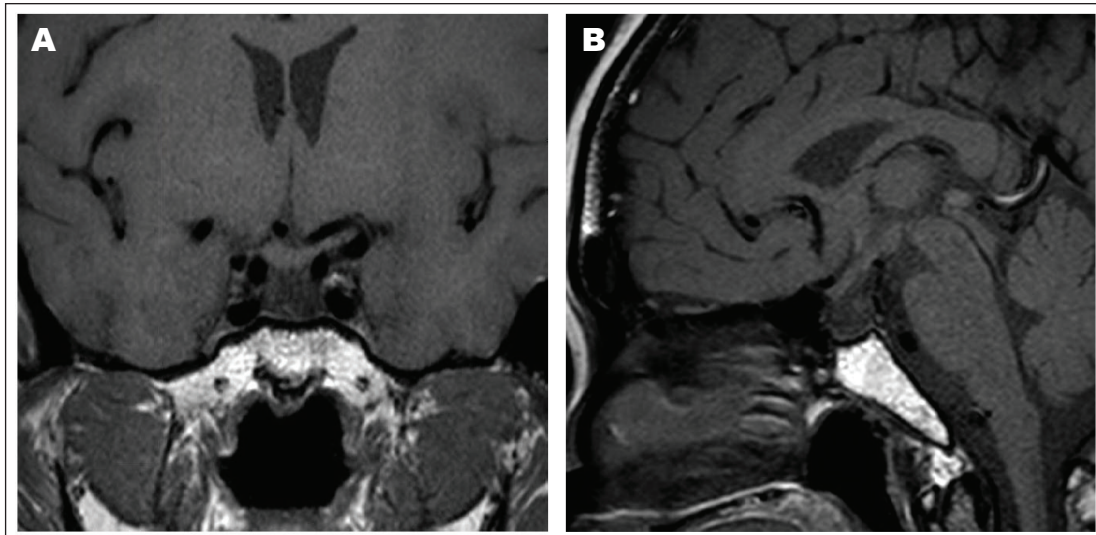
T1-weighted magnetic resonance images in the (A) coronal and (B) sagittal planes showing the patient's empty sella turcica.
